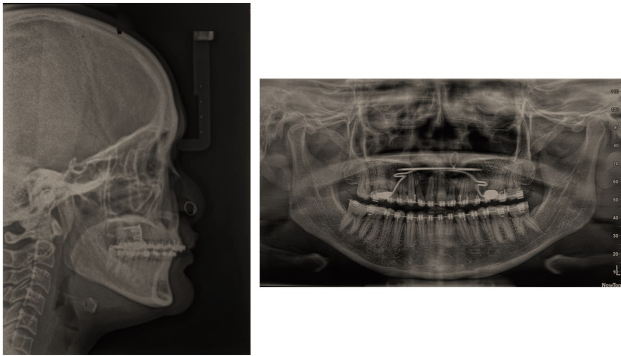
End of phase I radiographs
